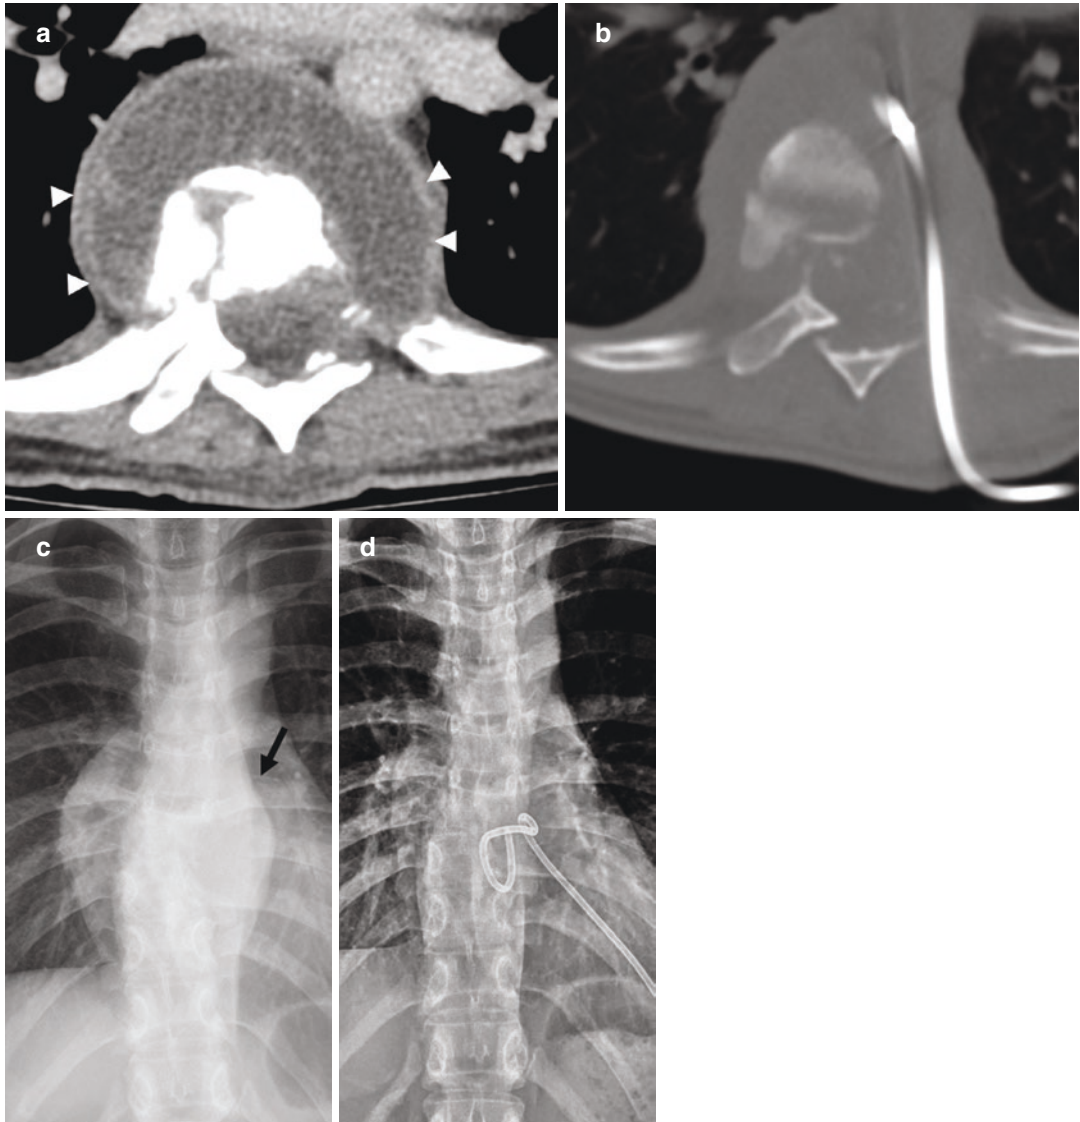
Tuberculous spondylodiscitis of the thoracic spine. (a) Axial contrast-enhanced CT image shows a large paraspinal abscess (arrowheads). (b) Axial unenhanced CT image obtained postdrainage of the abscess
